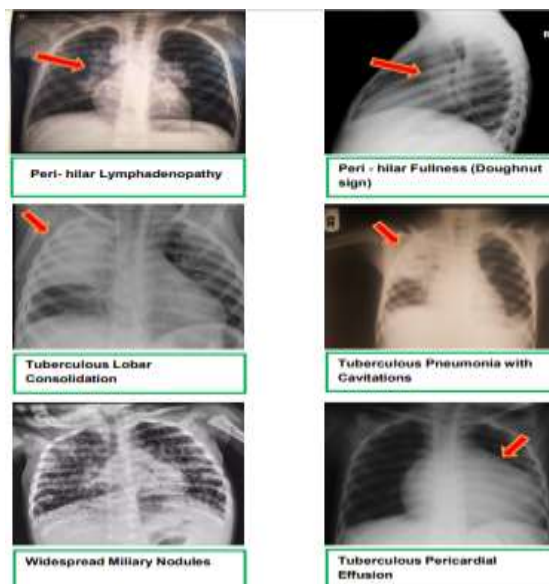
Some chest radiographic features of childhood TB
